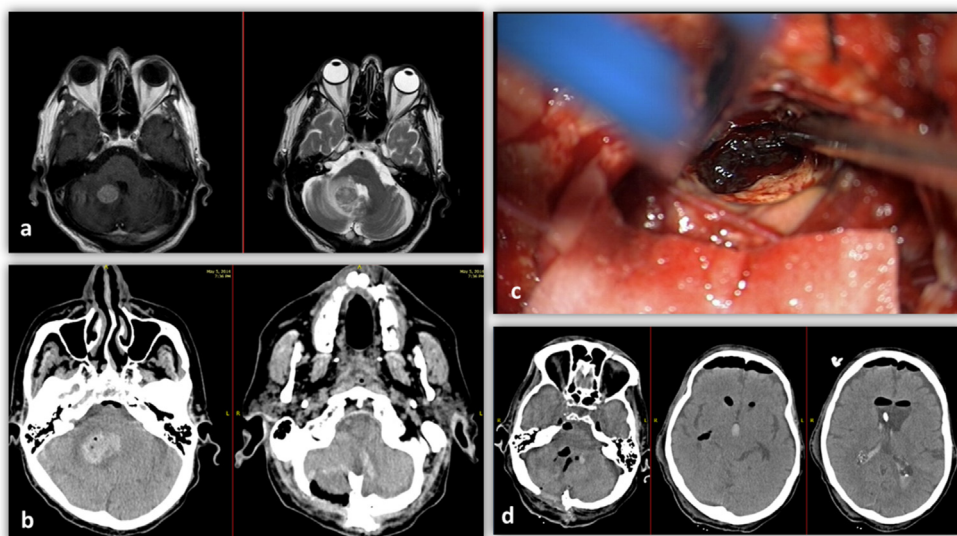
a: preoperative T1 with Gadolinium and T2-weighted MR images showing a parameian cerebellar metastasis in a 77-year-old male affected by melanoma (RPA class III, GPA score 1) associated to progressive consciousness deterioration. b: axial CT scan showing a post-operative hematoma in the surgical bed causing coma. c: intraoperative view during hematoma removal. d: post-operative CT scan after removal of the hematoma and external ventricular catheter positioning. The patient recovered only partially from his comatose state and died 15 days after surgery, due to nosocomial lung infection.
